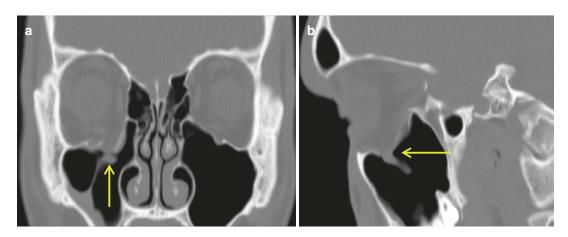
Bone windowed coronal (a) and sagittal (b) CT images show a right orbital floor 'blow out' fracture with soft tissue herniation into the maxillary antrum (yellow arrow)
